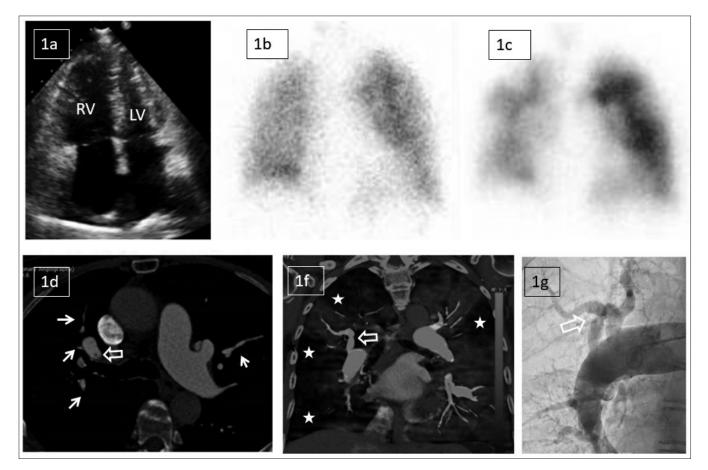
(a) Echocardiogram demonstrating grossly dilated right heart chambers suggestive of pulmonary hypertension (RV/LV ratio >1); (b) Ventilation portion of V/Q scan showing normal ventilation of both lungs (c) Perfusion portion of the V/Q scan showing wedge-shaped perfusion defects at peripheral lung fields; (d) Conventional CTPA; (e) Dual energy CTPA; (f) Invasive pulmonary angiogram. These images are from an elderly female patient who was diagnosed with CTEPH. Multifocal perfusion defects in both lungs (R>L) are demonstrated on both the V/Q scan and DECTPA (white stars). These perfusion defects correspond to the attenuated and occluded pulmonary arteries (white arrows) on the CTPA. Proximal dilatation and abrupt truncation (hollow arrow) of the distal portion of the right upper lobe branches was noted on both CT and invasive pulmonary angiogram.
